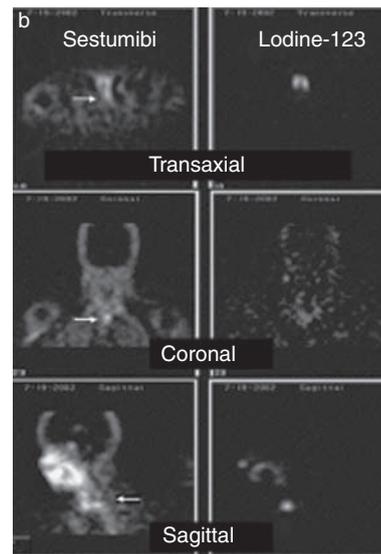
Imaging with iodine-123 and SPECT SestaMIBI scanning.
